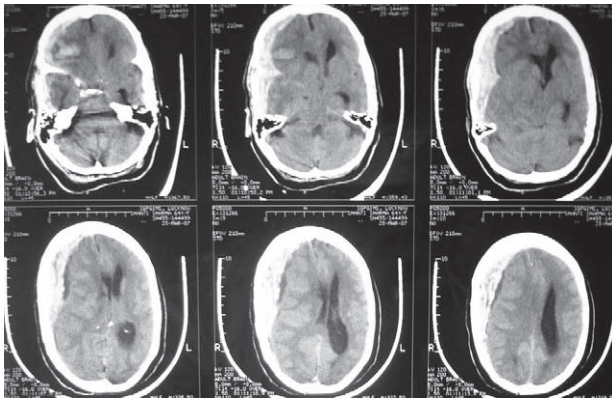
Non-contrast CT showing a large frontoparietal acute subdural hematoma with hemispheric mass effect and massive midline shift. There is associated right frontal contusion and no intraventricular blood.
